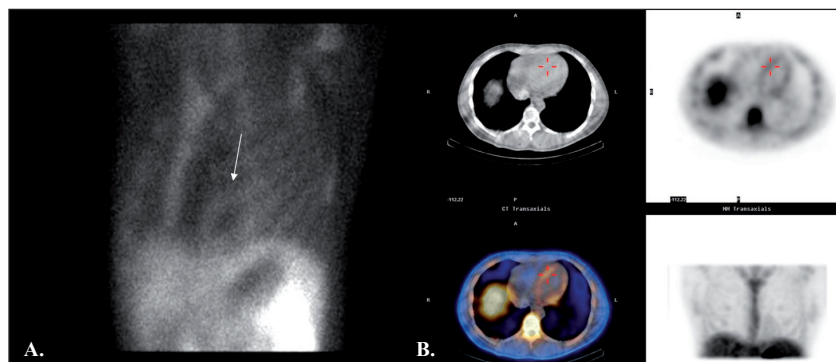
Images of case 1. A. Left anterior oblique planar view demonstrates increased depreotide myocardium uptake (white arrow). B. Transverse CT, SPET, fused and MIP images of the SPET/CT study confirm diffusely increased uptake in the left ventricle. Myocardium/rib uptake ratio =1.2 (upper normal limit = 0.94).
